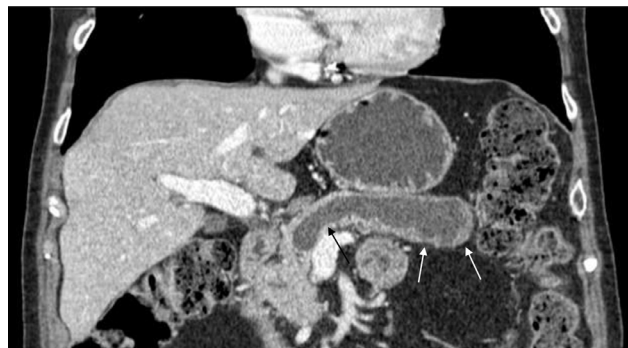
Coronal reconstructed contrast-enhanced CT of the abdomen obtained in October 2011 shows a low attenuation mass in the pancreatic body and tail (arrows) contiguous with the main pancreatic duct which is markedly dilated (black arrow).
